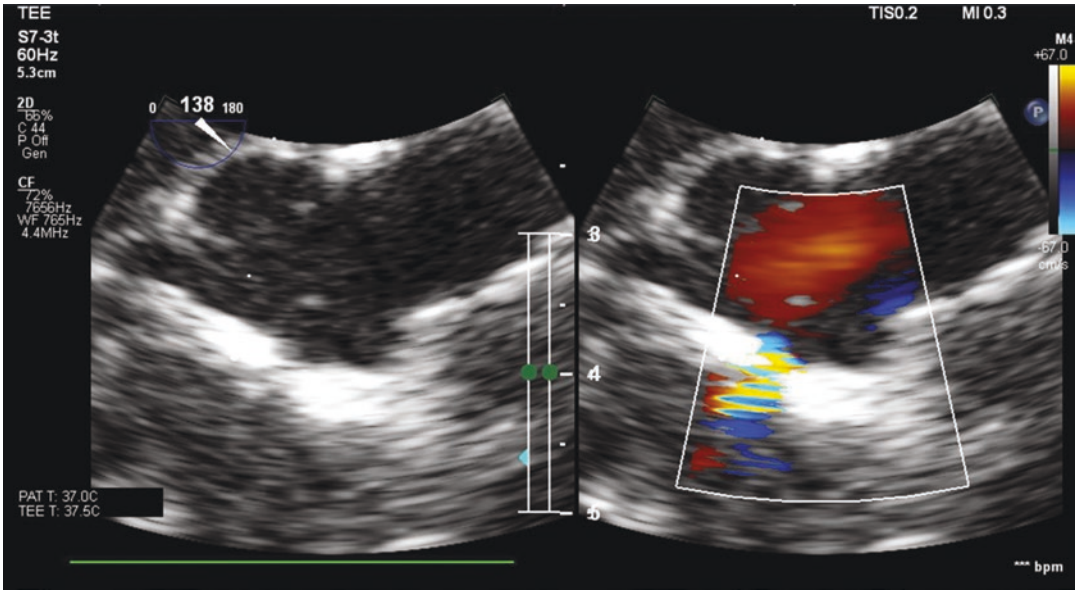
Modified sagittal, zoomed-up view, demonstrating the aortic valve and VSD patch (bright linear structure), which unlike the 4 chamber view, reveals a small residual patch leak seen by color Doppler mapping (blue jet)
